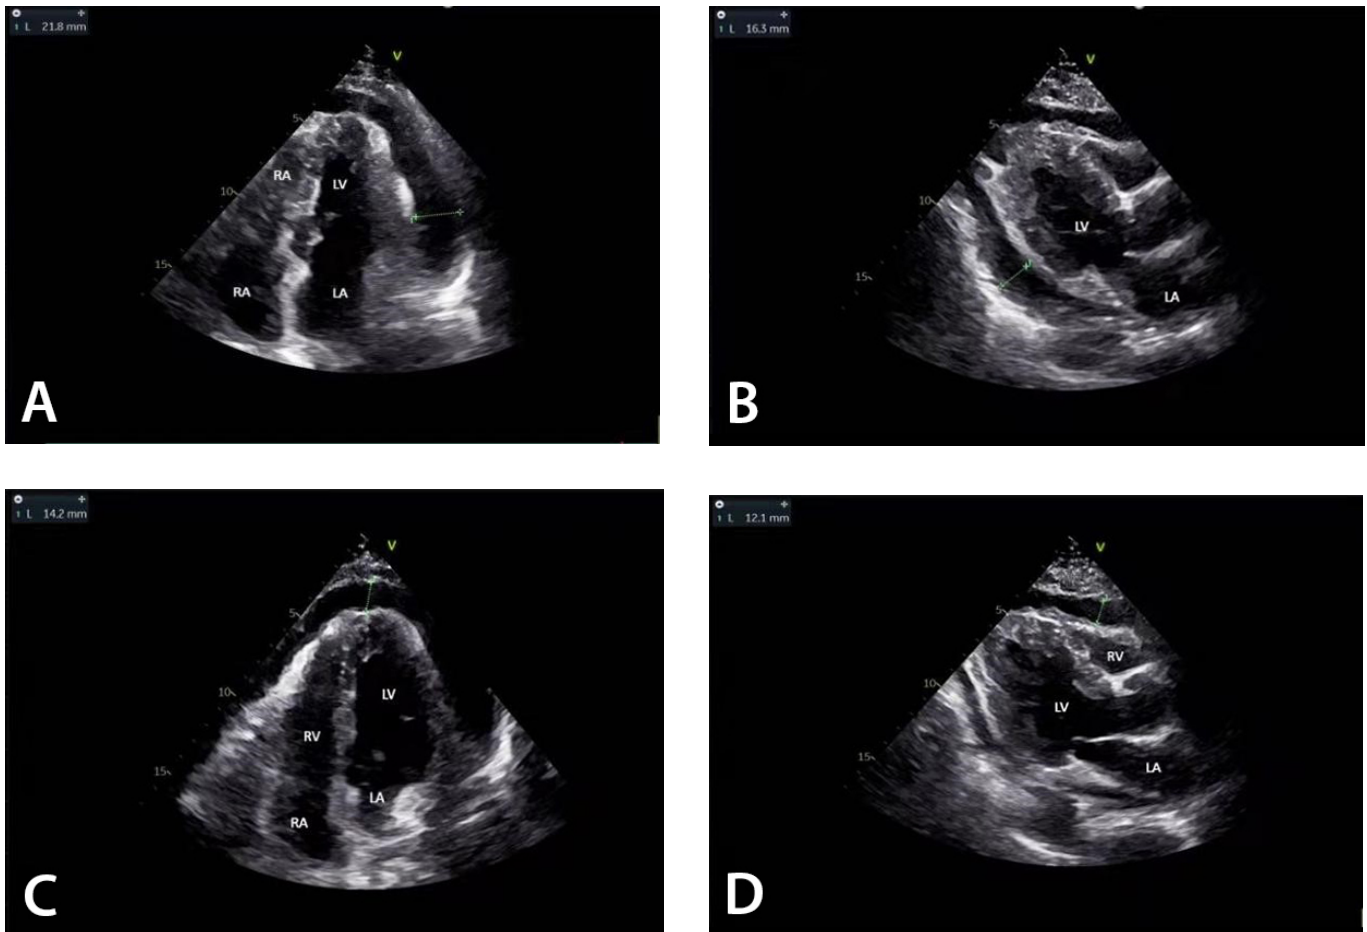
Bedside color Doppler ultrasound was performed to determine the location of effusion and/or associated pericardial thickening. The effusion was mainly located in the posterior wall of left ventricle (LV) (A), left ventricular wall (B), right ventricular wall (C), and cardiac apex (D). LA=left atrium; RA=right atrium; RV=right ventricle.
